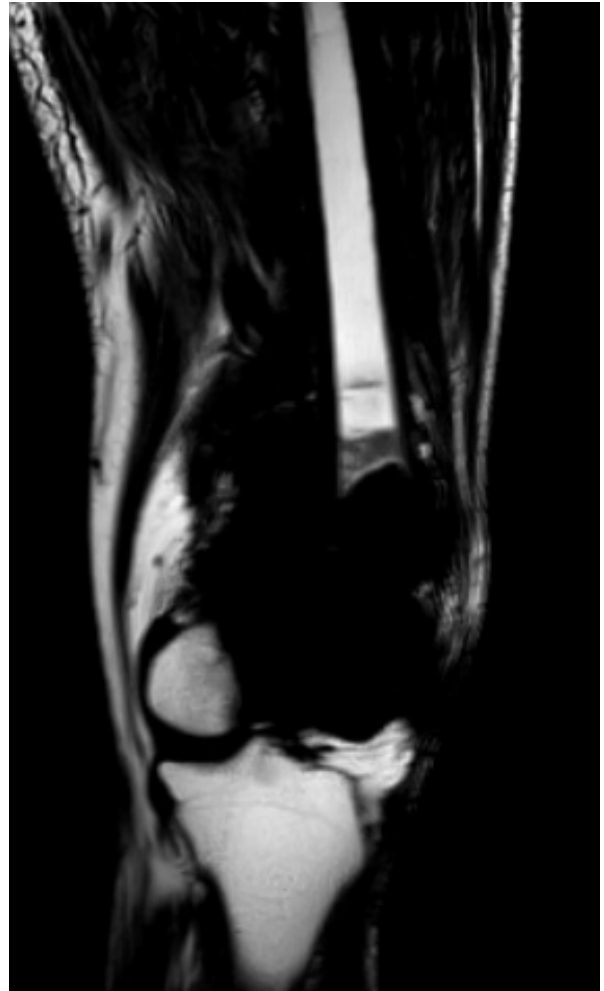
MRI-T2W m DIXON coronal image
